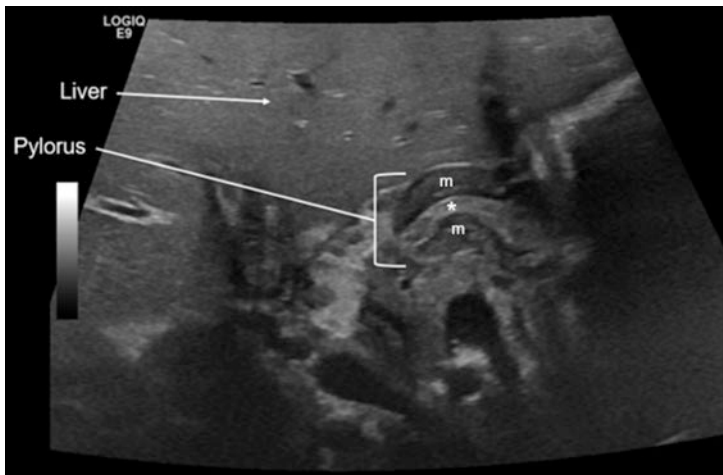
The pylorus is the distal portion of the stomach where it empties into the duodenum. This is an ultrasound image of a normal longitudinal view through the pyloric sphincter in a newborn infant. m = pyloric muscle. * = pyloric canal
